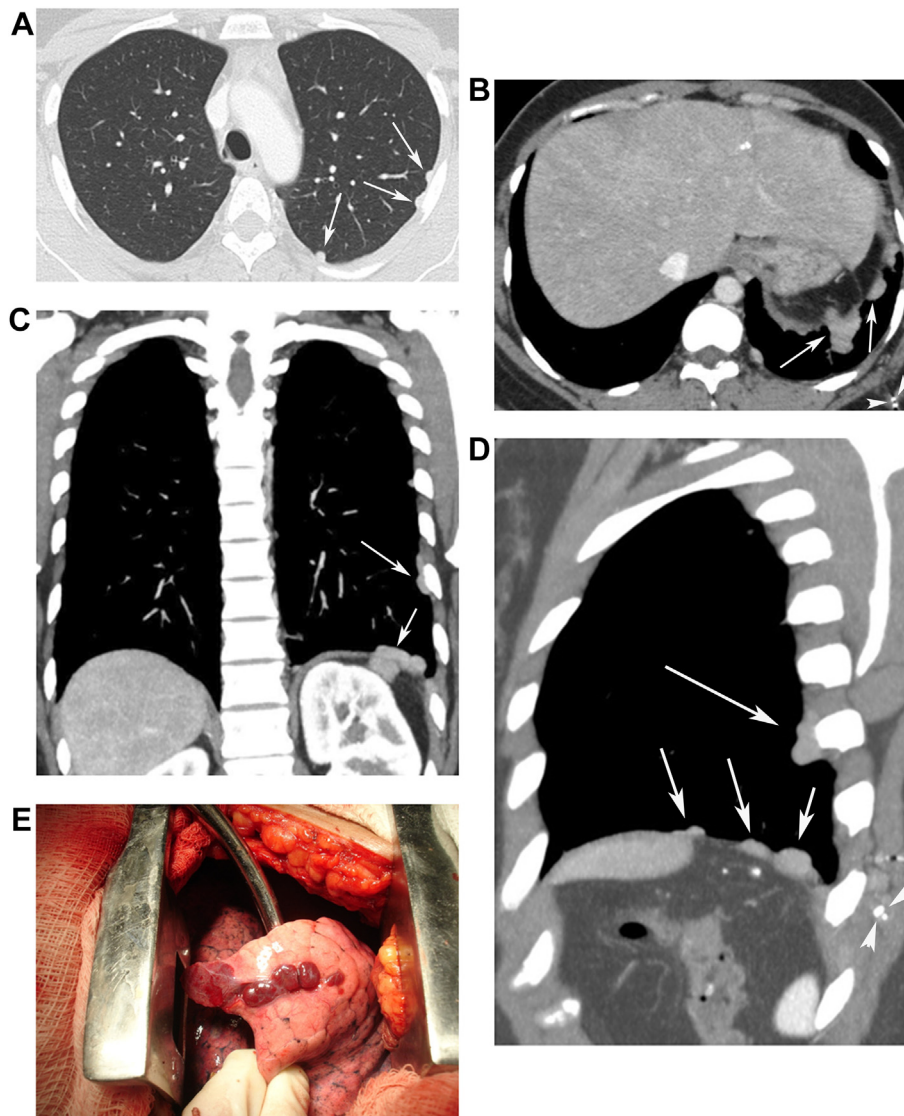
An asymptomatic 58-year-old woman with thoracic splenosis. She reported a history of a gunshot wound that transixed the thoracoabdominal region 40 years previously. Computed tomography (A–D) shows a lobulated pleural mass and well-circumscribed pleural-based nodules in the left hemithorax (arrows). Note also the absence of the spleen in the left upper quadrant, a nodular opacity that corresponds to a residual spleen parenchyma, and metallic bullet fragments in the chest wall (arrowheads). Thoracotomy (E) disclosed multiple reddish-purple nodules on the pleural surface (Fig. 1E reprinted with permission from Marchiori E, Rodrigues RS, Reis MC, Zanetti G, Menna Barreto M. Pleural nodules in a patient with a colonic tumor. *Thorax* 2014; 69 (4):395–398).
